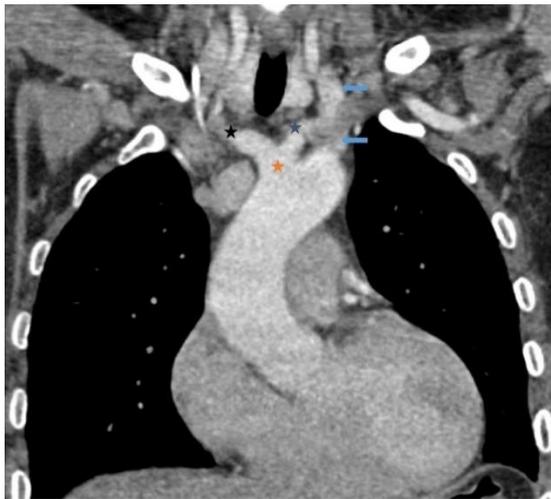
Chest CT in oblique coronal section: visualization of the aberrant right subclavian artery (blue arrow), bicarotid common trunk (orange star) subdividing into right common carotid artery (black star) and left (grey star)
